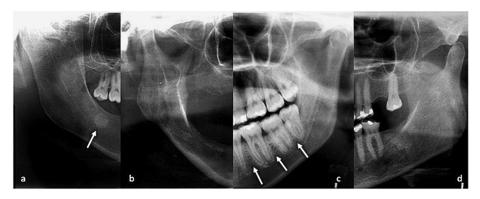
Cropped panoramic radiographs showing the radiographic alterations observed in patients with sickle cell disease: (A) Radiopaque areas in jaw bones (arrow), (B) increased spacing of bone trabeculae, (C) horizontal arrangement of bone trabeculae (arrows), (D) absence of mandibular canal corticalization.
